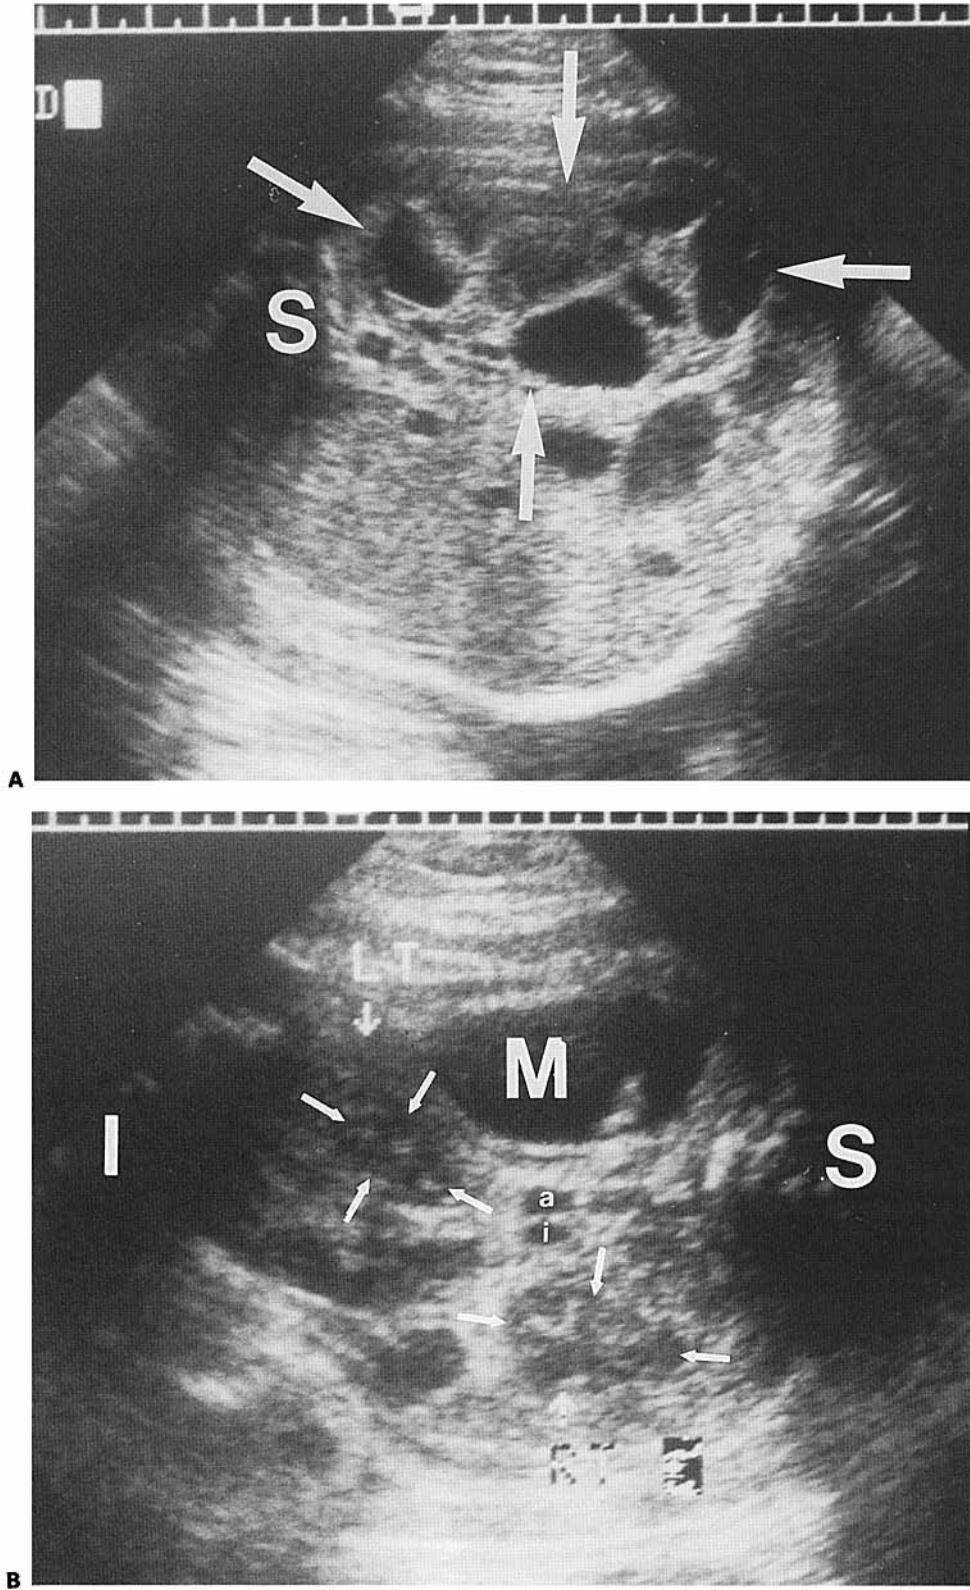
(A) Transverse sonogram of the fetal abdomen at 34 weeks, MA. The fetal left upper quadrant mass (arrows) is now complex with cystic and solid components, and was larger than 4 weeks previously (S: spine). (B) Coronal sonogram of the fetal abdomen at 34 weeks, MA. This plane is through a cystic component of the mass (M). The left kidney (LT, arrows) is inferiorly displaced by the mass (RT, arrows: right kidney; S: superior in fetus; I: inferior in fetus; a: aorta; i: inferior vena cava).
